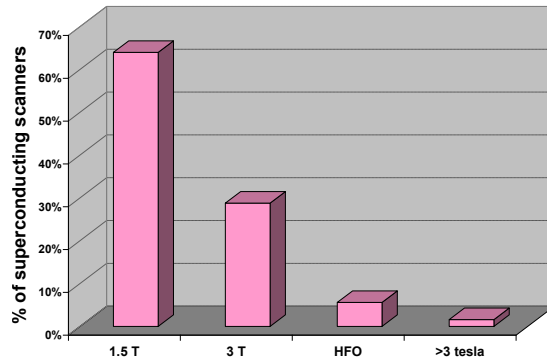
Delivered superconducting MRI systems by field strength (2008)
